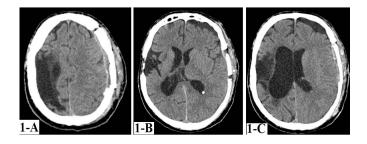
CT cerebral scan control (on 20.05.2019, after two consecutive neurosurgical interventions).
